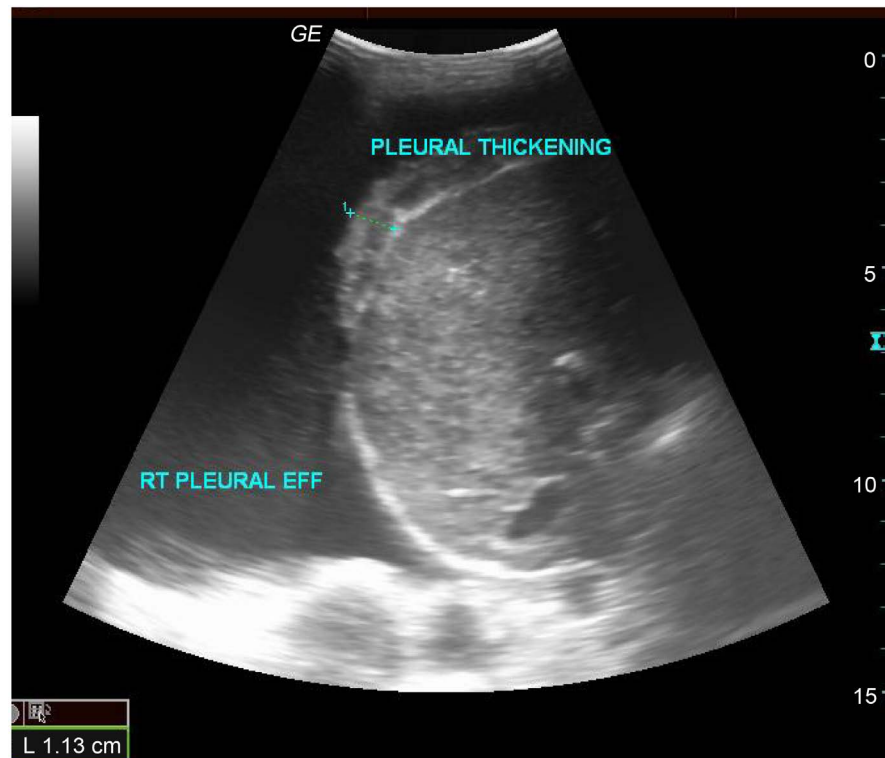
Sonographic appearance of pleural thickening.
